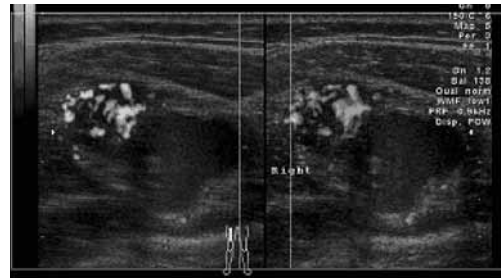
Hypervascularized area with sonographic characteristics of vascular malformation (hemangioma) positioned closely to the hematoma ventrolaterally in the proximal third of the thigh (horizontal orientation).
